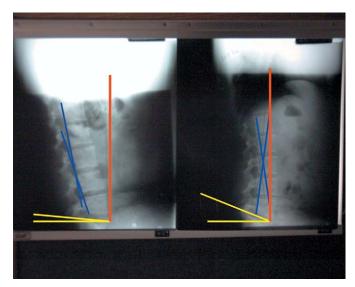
Shows the pre (left) and post (right) lateral lumbar radiographs. The yellow lines represent the sacral base angle (Ferguson's angle). This value increased from 4° to 18° posttrial. The blue lines represent the lumbar curve measurement from L1 to L5. This number also increased from a 5° kyphosis to a 14° lordosis after the trial period. The red line is the same gravity line as the red line in figure 3. According to Kapandji (11), this line should intersect the posterior third of the L3 vertebral body.
